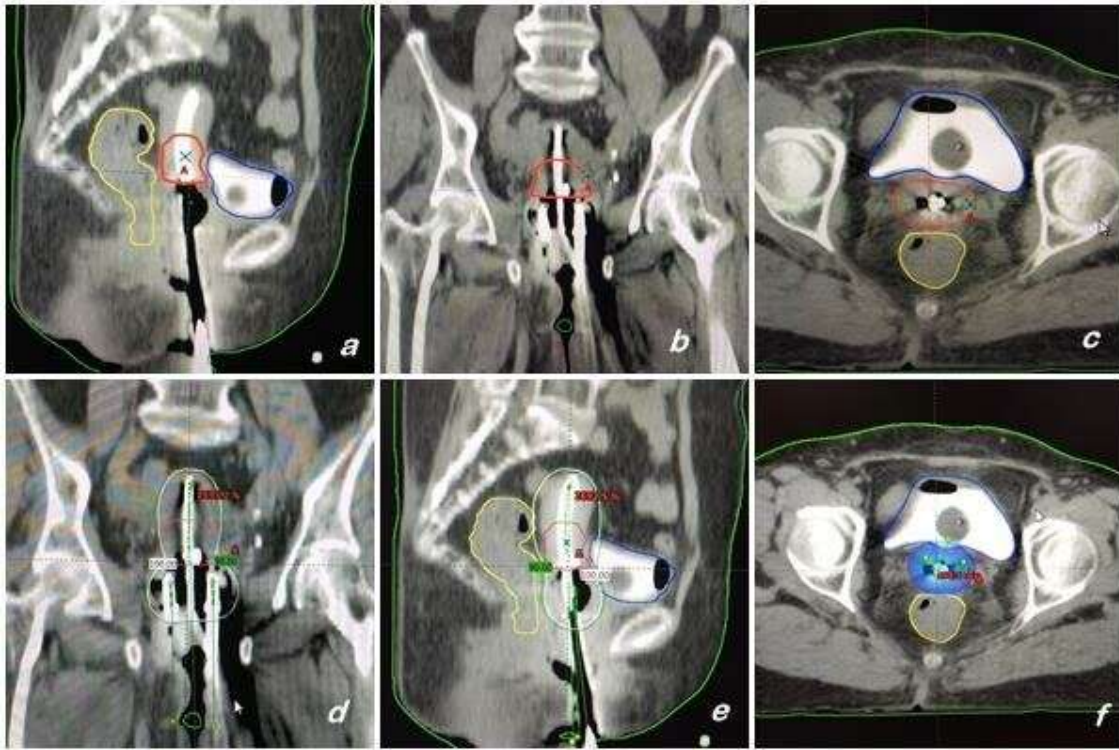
Axial CT showing HR-CTV contour (red) and isodose distribution (green = 90%, white = 100%) in MRI-guided planning. Reproduced from Bandyopadhyay A, Ghosh AK, Chhatui B, Das D, *Reports of Practical Oncology & Radiotherapy* 2021;26(2):170–178. Licensed under CC BY-NC-ND 4.0.
